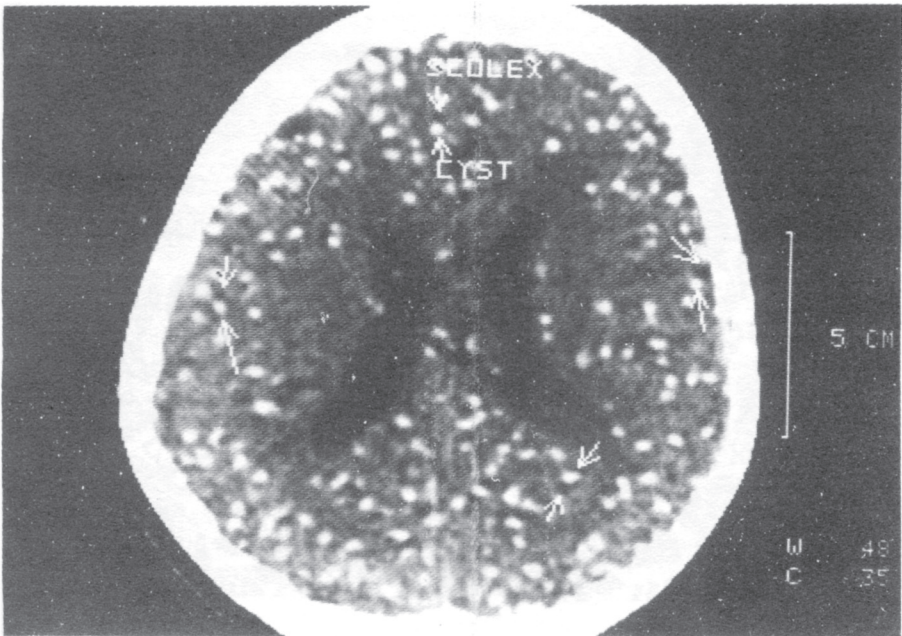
An unenhanced CT scan of the brain showing a vast number of living cysticerci giving "a sky on a starry night" effect. The scolex and cyst are marked by arrows.
